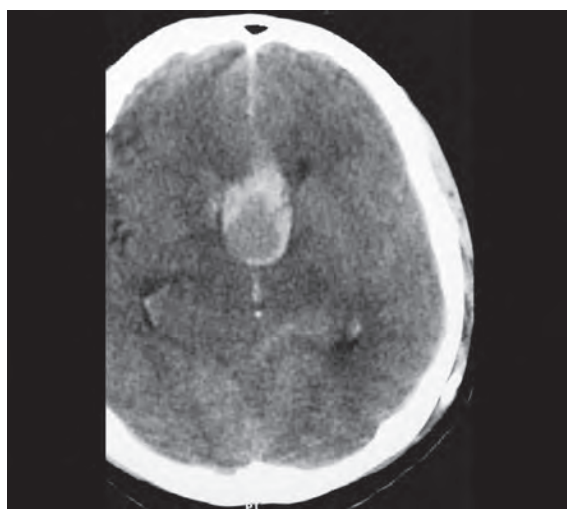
The CT scan brain showing large globular ACoAA
